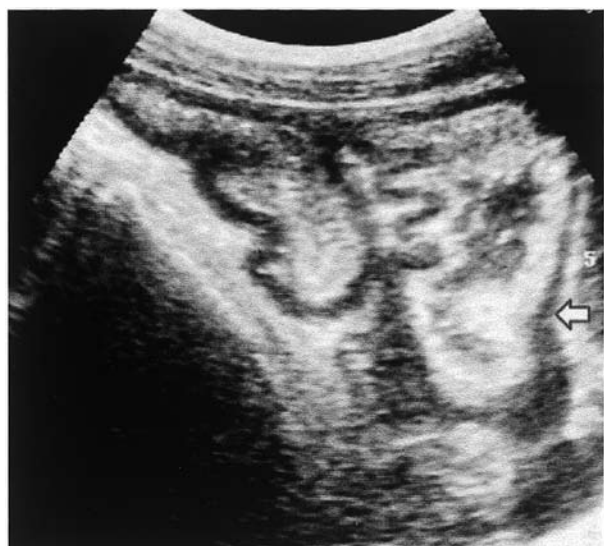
Abdominal sonography indicated wall thickness of the bowel (arrow), as in the findings of the CT.
